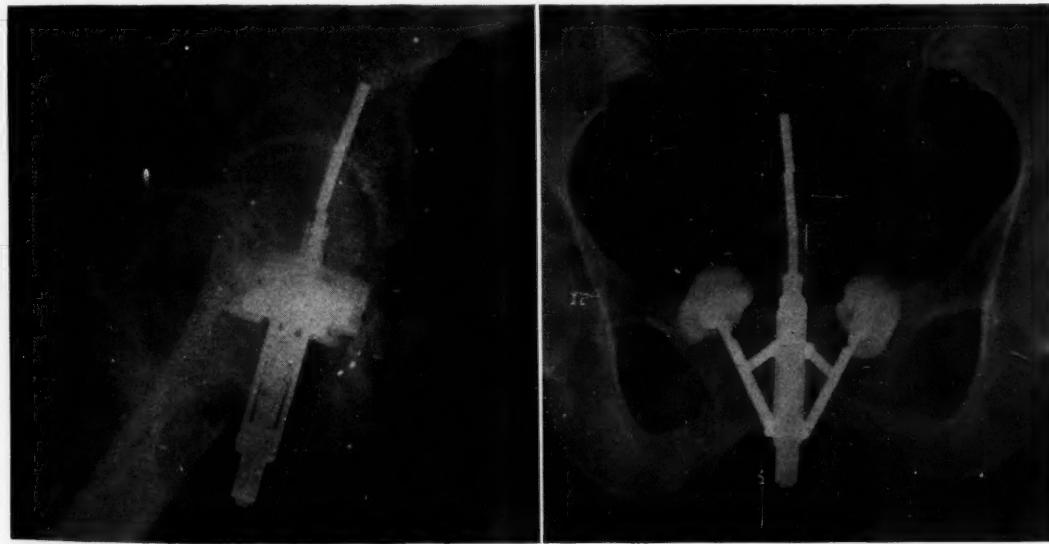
Lateral and anteroposterior roentgenograms showing the position of the colpostat in a pelvis.
